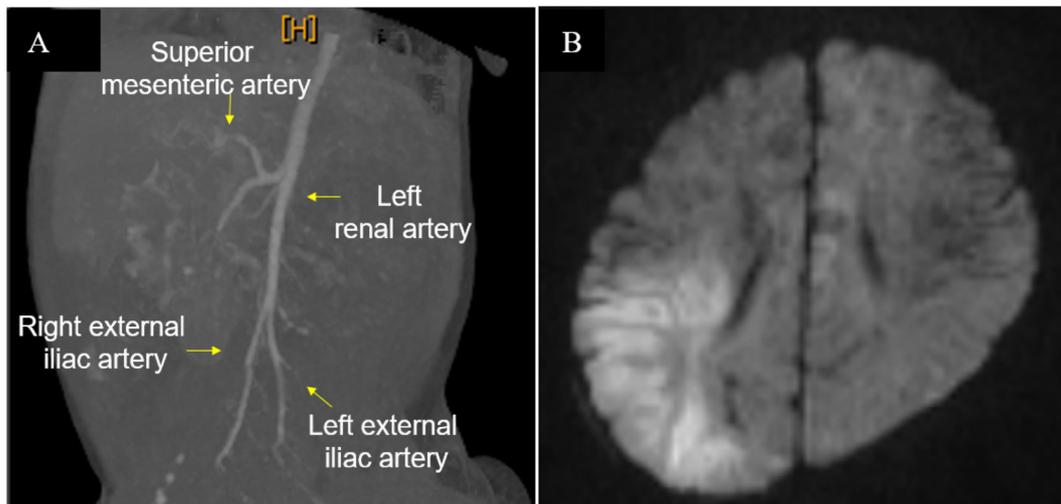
At 85 days after birth, 3-dimensional CT image (A) shows occlusion and stenosis of the superior mesenteric, left renal, and bilateral external iliac arteries. On DWI MRI images, a right median cerebral artery infarction is visible (B).
